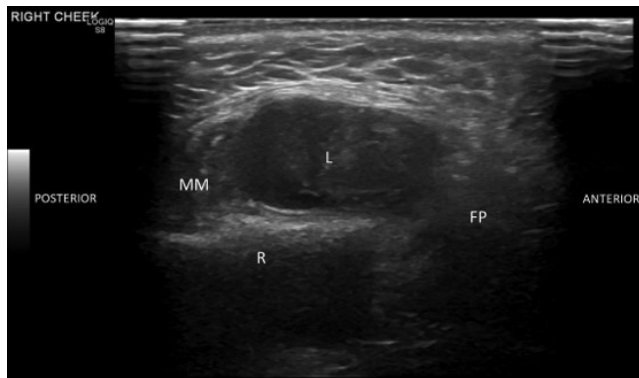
Ultrasound image of the transverse right cheek showing the lesion positioned anterior to the main body of the masseter muscle (MM), superficial to the mandibular ramus (R) and posterior to the buccal fat pad (FP)
